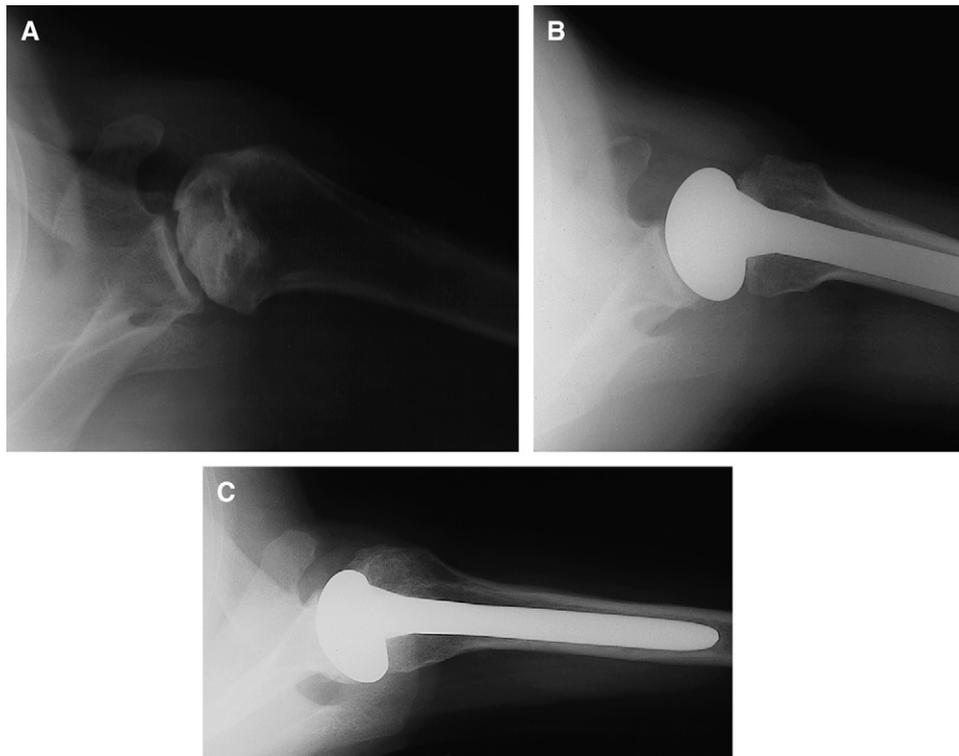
A, Preoperative radiograph of 39-year-old man with steroid-induced ON. He had 100° of active elevation, 20° of external rotation, and severe pain. B, Immediate postoperative radiograph. C, Thirteen years after hemiarthroplasty, he has moderate pain with 140° of active elevation and 50° of external rotation.
